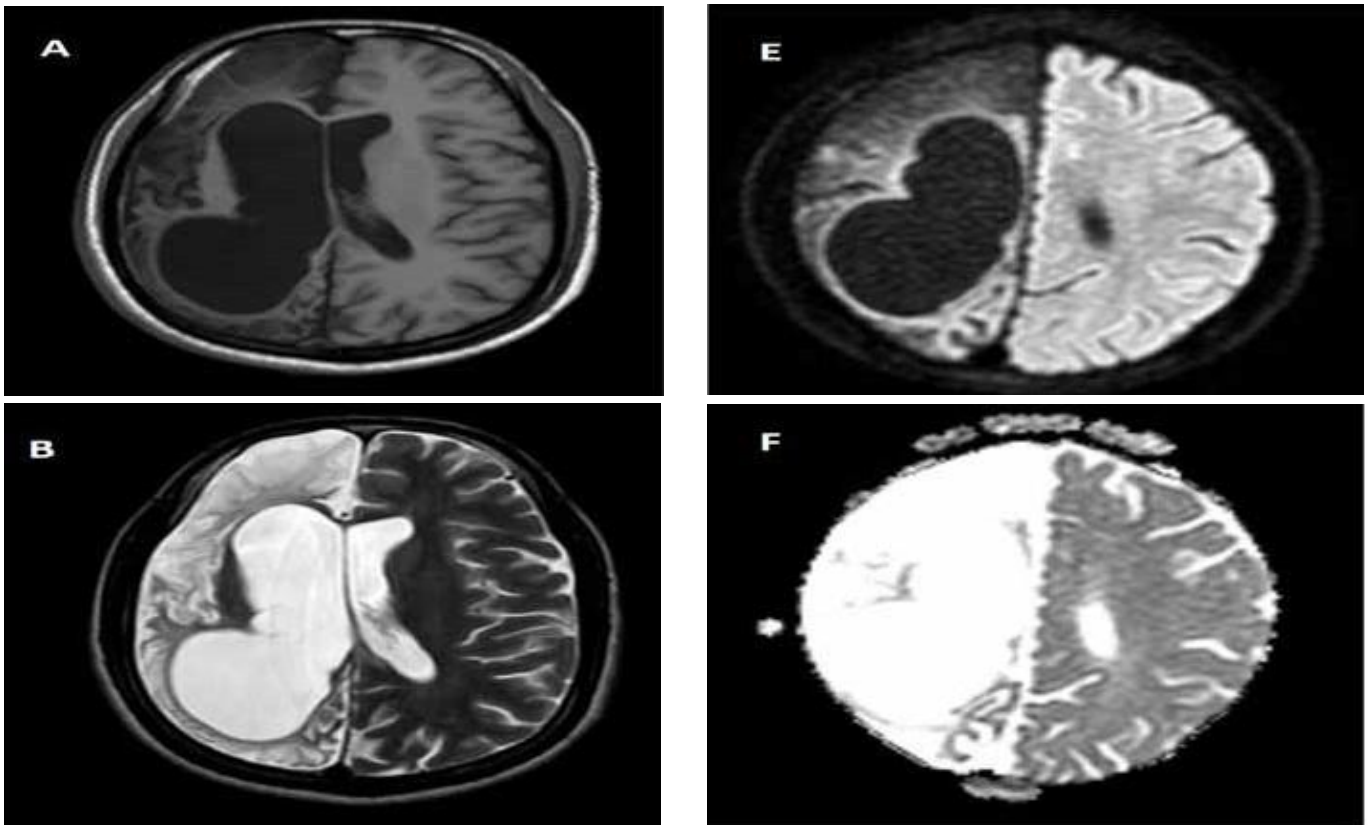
T1 weighted (A), T2 weighted (B) and FLAIR image (C) of MRI brain in axial plane shows atrophy of right cerebral hemisphere with ex-vacuo dilatation of ipsilateral lateral ventricle. GRE sequence (D) do not show foci of blooming artefacts. DWI/ADC sequences (E and F) do not show areas of diffusion restriction.
